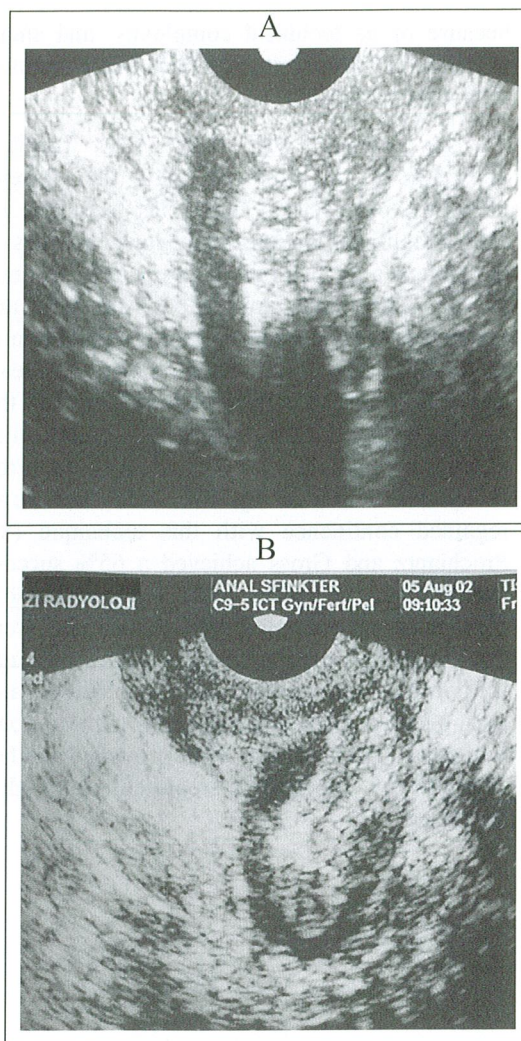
Transvaginal ultrasound of the anal sphincters demonstrated an almost complete loss of the sphincter muscles preoperatively (A), and the complete muscle wrap around the anal canal postoperatively (B).
